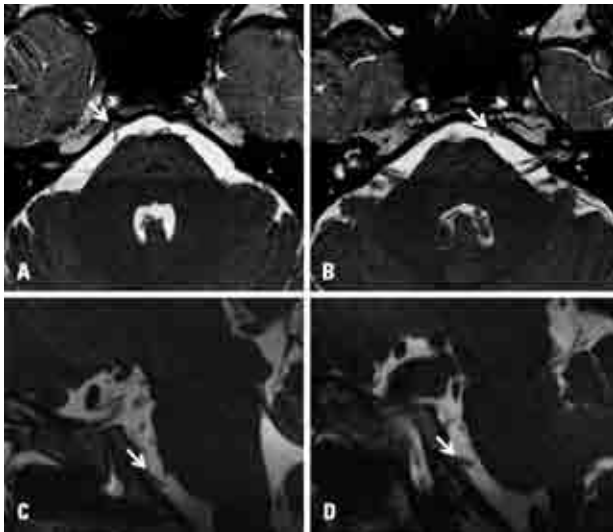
MRI study 1-year after trauma showing discontinuity on the cisternal segment of the VI nerve (complete avulsion) on the right [A and C] and on the left [B and D]. Oblique axial [A and B] and oblique sagittal [C and D] FIESTA reformatted images.
